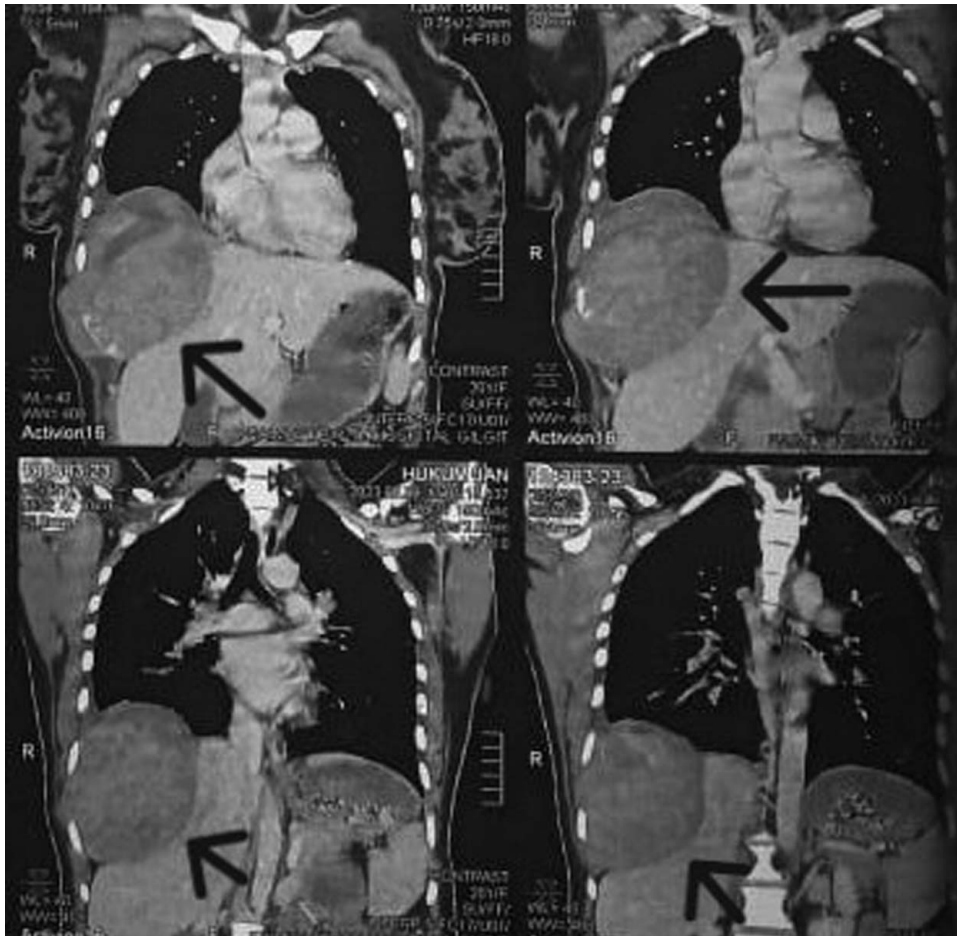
Different slides of coronal section of computed tomography scan chest and abdomen showing heterogeneously enhancing soft tissue density mass in the right lower hemithorax causing erosion and osteolysis of right 9th rib, involving intercostal muscles and exerting mass effect on underlying hemidiaphragm.
